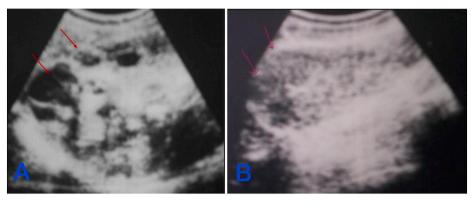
Ultrasound of the urinary tract: Heterogeneous echogenic formation of the upper pole of the right kidney (A). Heterogeneous formation along the right psoas (B).
